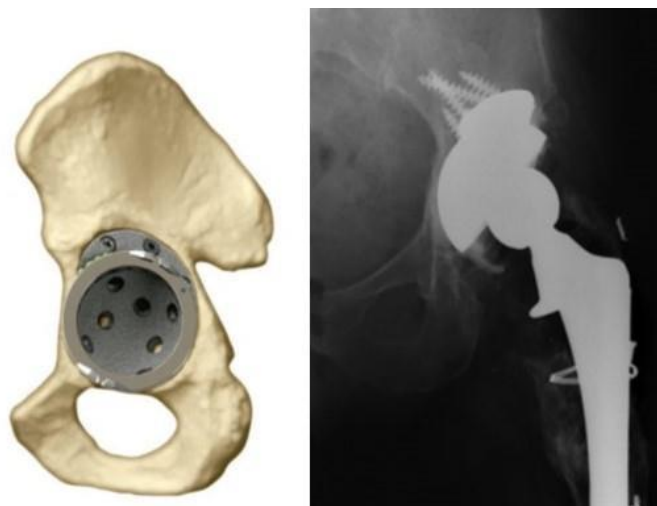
Oblong cup position. Algorithmic and postoperative X-ray ⁽⁷⁴⁾.
